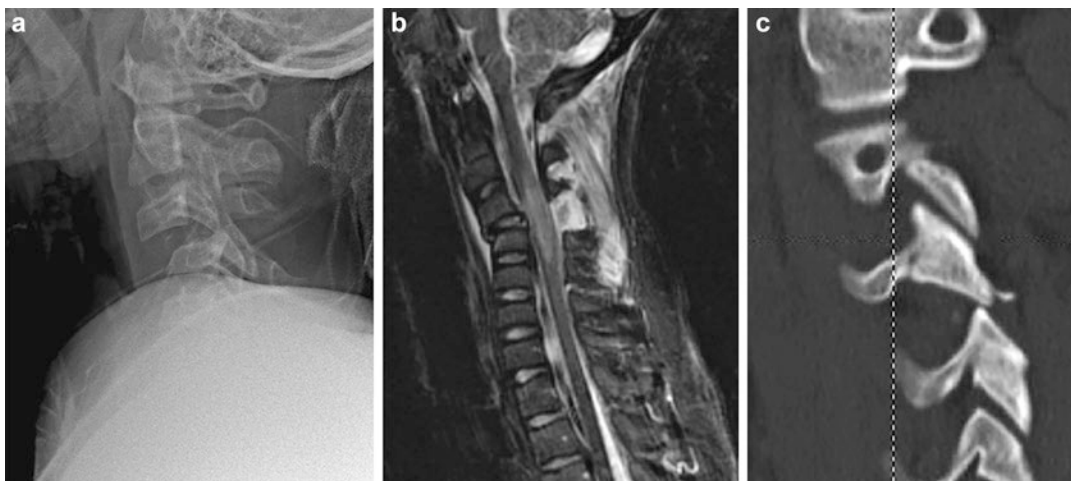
(a–c) (a) Lateral radiograph of the cervical spine in a 13-year-old male who sustained a neck injury while playing hockey. Note the displacement suggestive of a facet dislocation. (b) MRI showing the significant signal changes at the facets and posterior interspinous
